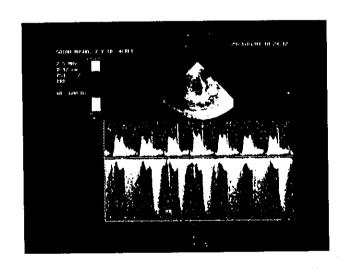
Echocardiography of 13 years old female patient with CRF shows MR.
